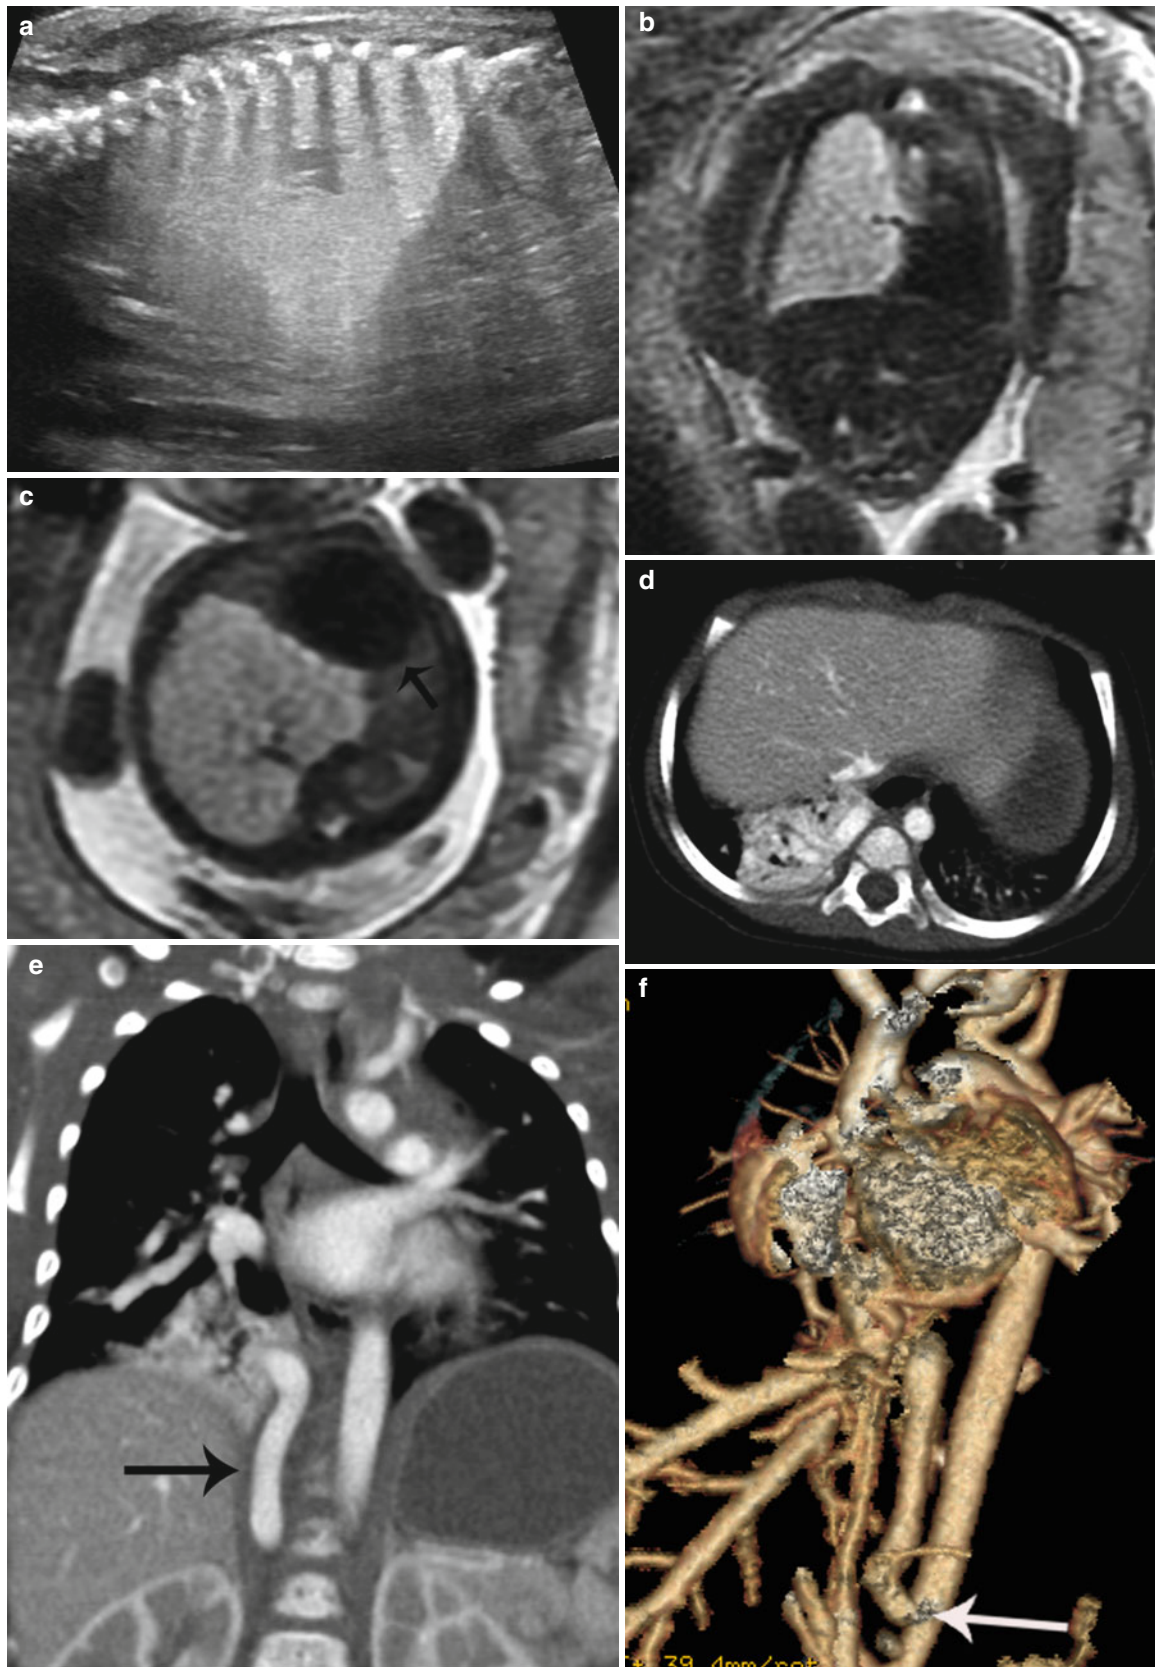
Hybrid CPAM BPS at 23 weeks gestation. (a) Sagittal US image demonstrates a large echogenic mass inverting the diaphragm. A few macrocysts are noted centrally. (b) Coronal and (c) axial SSFSE MR images demonstrate a high-signal mass deviating the heart to the right (*arrow*). CVR was 1.7. No definite systemic feeding vessel was identified. Patient was asymptomatic at delivery. (d) Axial CT at
